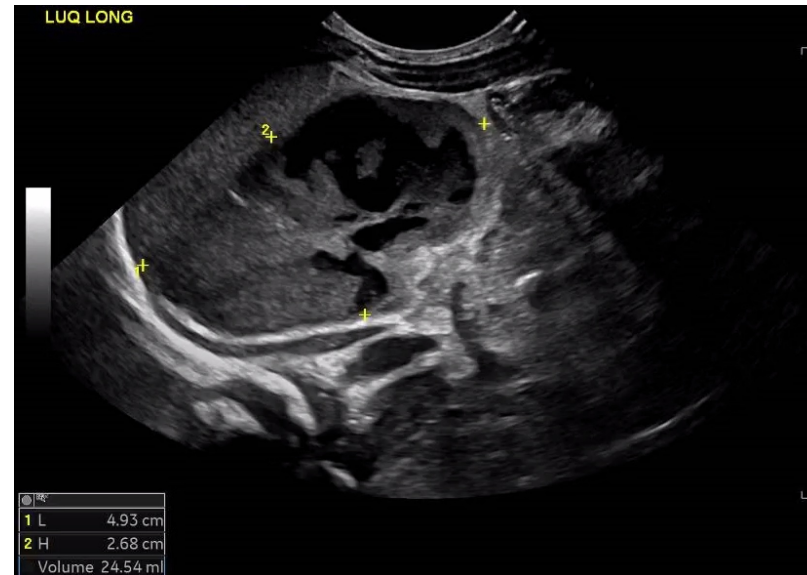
Ultrasound appearance of adrenal haematoma at presentation, measuring 49mm by 35mm by 27mm initially. Mass effect on an anatomically normal stomach was noted.
